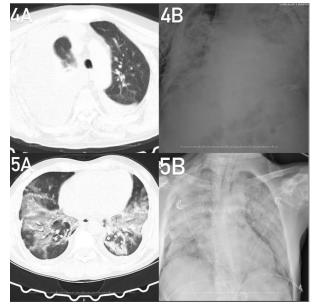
Chest X-ray and CT scan of dead cases. 4A, and 5A imaging at admission.
